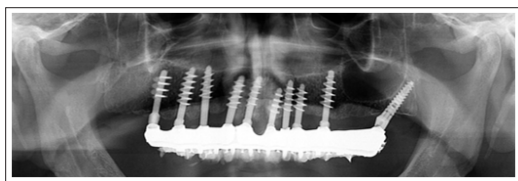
Six Year X-Ray Check
